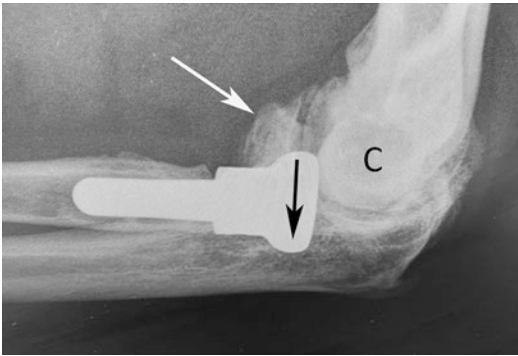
Lateral radiograph showing residual posterior subluxation of the radial head (black arrow). Note that there is significant periarticular elbow joint arthritis (white arrow). Capitellum (C)
